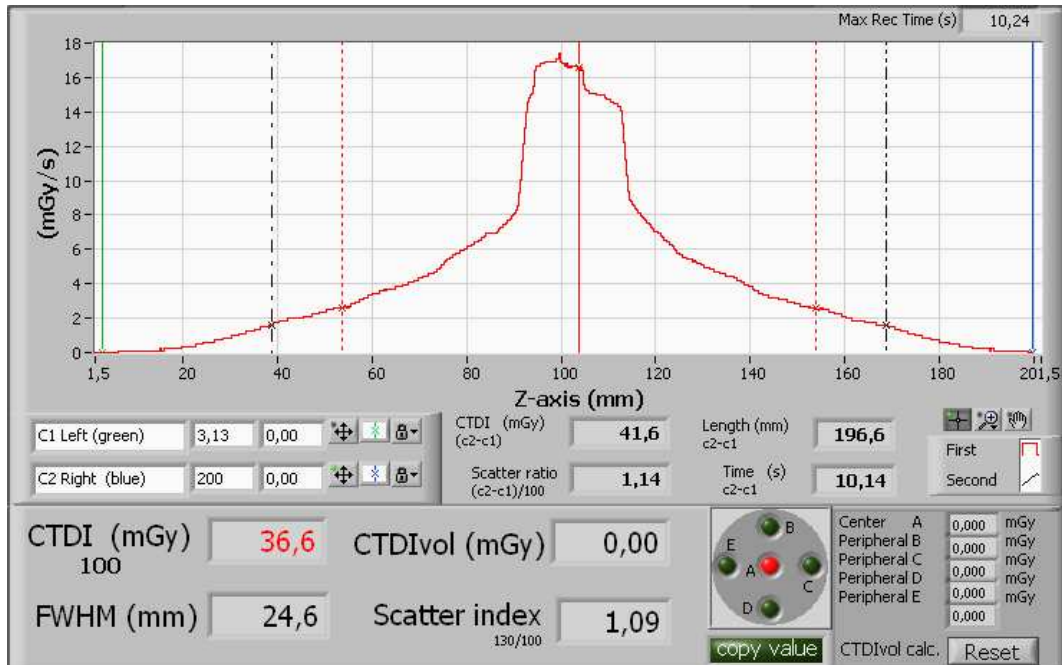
The detected signal during three rotations of the CT-SDD2
